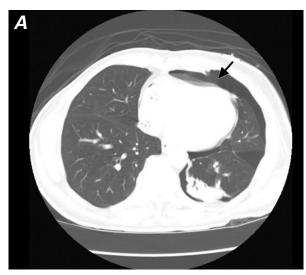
Noncontrast computed tomographic images of the chest obtained through A) parenchymal and B) mediastinal windows show left basal pneumothorax, collapse of the ipsilateral lung parenchyma, and pneumopericardium (asterisk) resulting from communication between the pleural and pericardial spaces (arrows).
